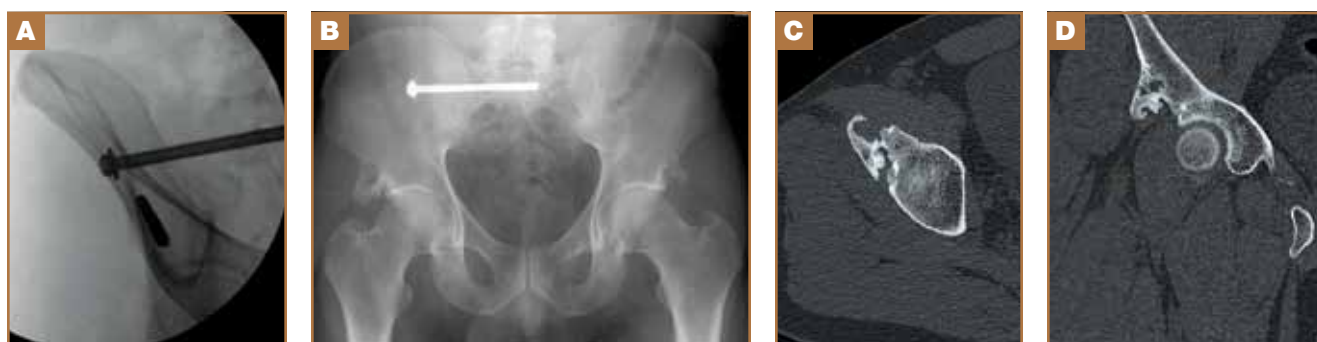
An intraoperative fluoroscopic image from the index procedure demonstrating placement of a right-sided AIIS Schanz pin (A). AP pelvic radiograph 26 months after pelvic stabilization with an anteroinferior external fixator and right-sided posterior SI screw fixation (B). Axial CT image of right AIIS exostosis (C). Coronal CT image of right AIIS exostosis (D).
